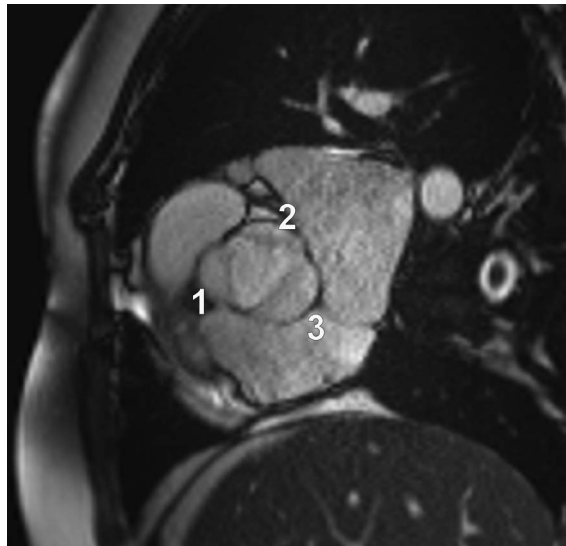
Tricuspid aortic valve. Annotated. Heart. MRI. Steady-state free precession. Contrast enhancement. Axial plane. Level through the aortic valve. 1, 2, 3 = aortic valve cusps.
